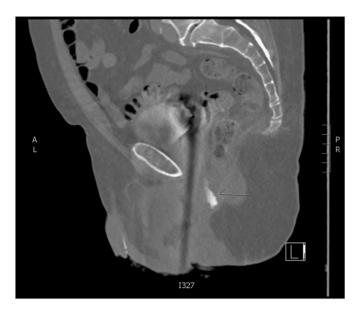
Ascending CT urethrogram demonstrating urethral fistula at the membranous urethra.
